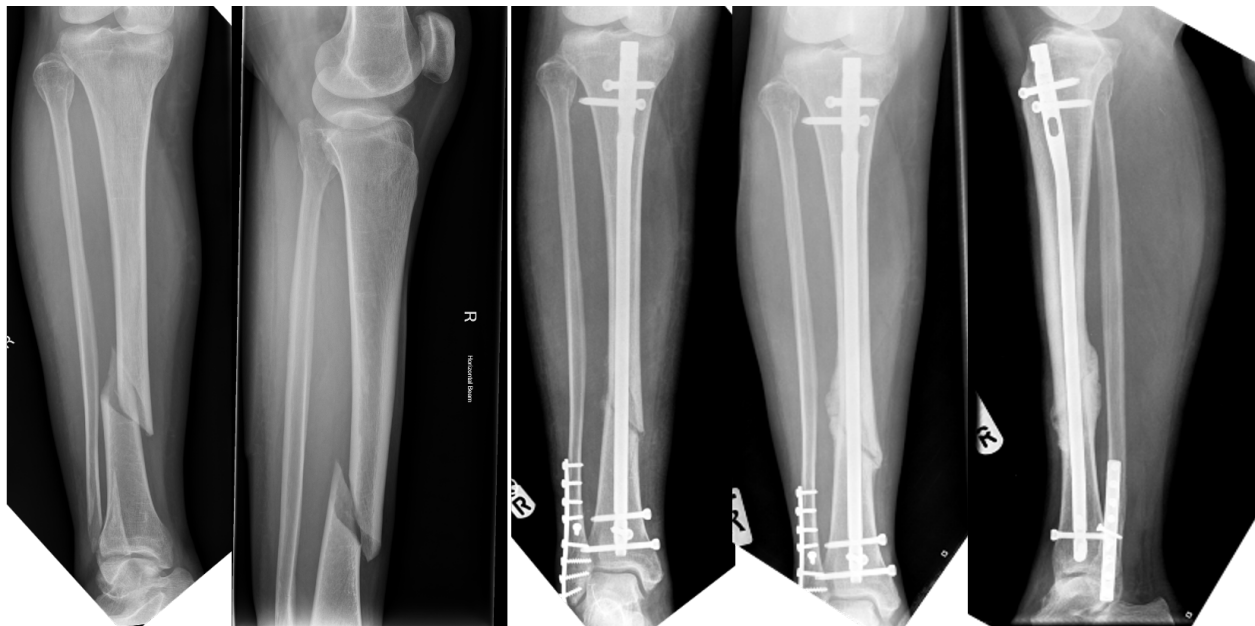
Simple type 42A1 tibia fracture managed with intramedullary nail (IMN). From left to right: AP of initial radiograph of initial injury, lateral radiograph of initial injury, first post-op radiograph with IMN in situ and fibular fixation, Final AP and final Lateral images showing bridging callus on all four cortices.
